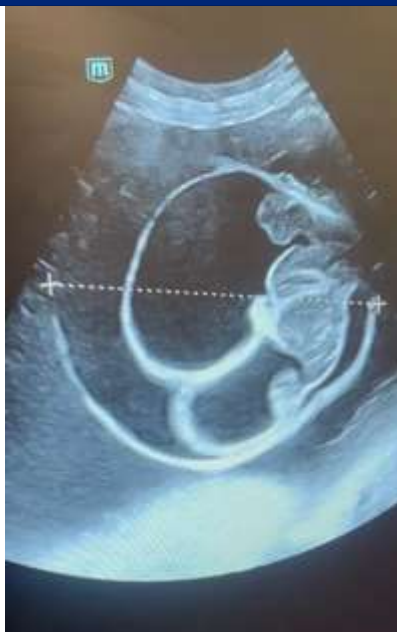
39-week fetus, ultrasound shows a median occipital bone defect with cerebral parenchyma protrusion associated with isolated encephalocele.
